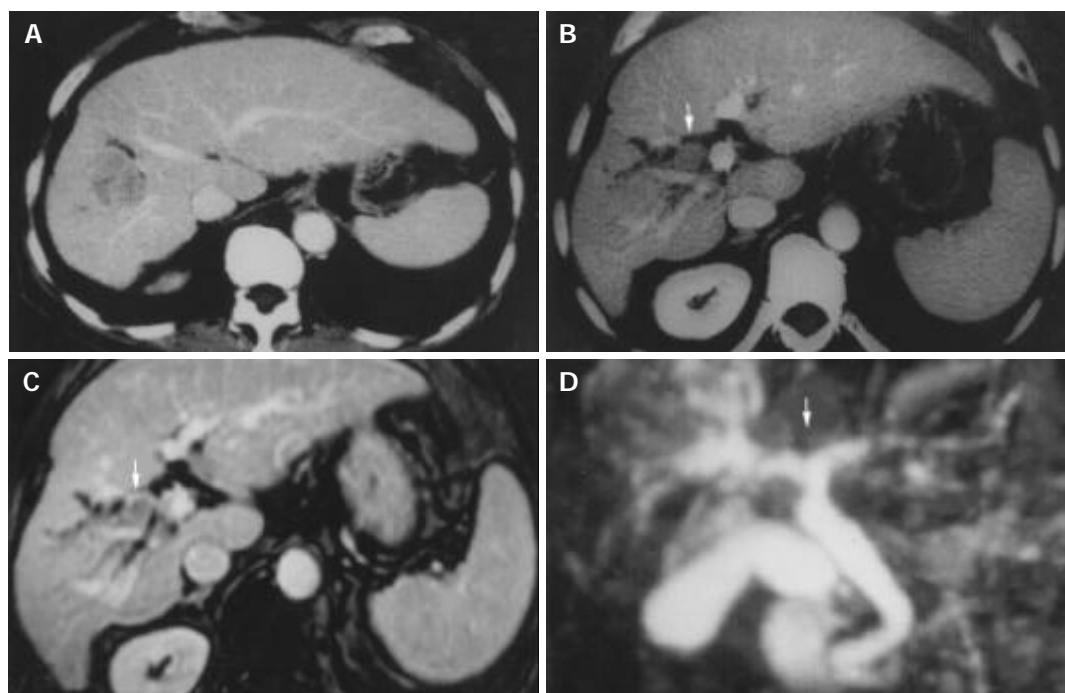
The imaging diagnosis of hepatocellular carcinoma with thrombosis in bile duct. A and B are pictures of CT scan, C and D are pictures of magnetic resonance cholangiography (MRCP). These pictures show the primary tumor in right anterior lobe of the liver, with tumor thrombosis in common hepatic duct (arrow).
